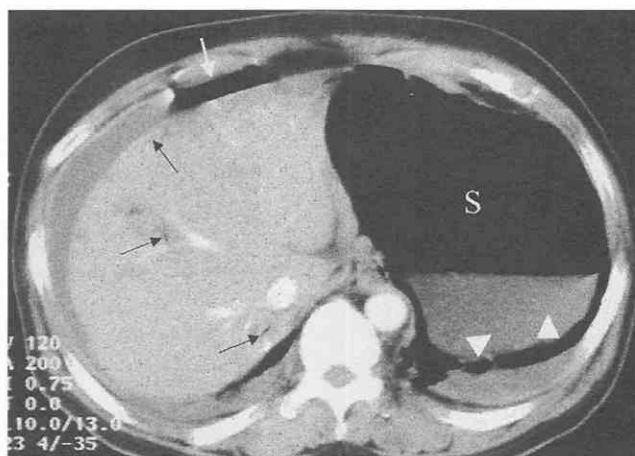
Corrosive gastritis with pneumatosis in the gastric wall and multifocal hepatic infarction. CT scan shows intramural gas (arrowheads) along with pneumoperitoneum (white arrow) and ascites due to gastric perforation. Also noted are intrahepatic portal vein gas (thin arrows) caused by hepatic infarction. (From Rha SE, Ha HK, Lee SH, et al: CT and MR imaging findings of bowel ischemia according to the various primary causes. *Radiographics* 20:29-42, 2000.)
